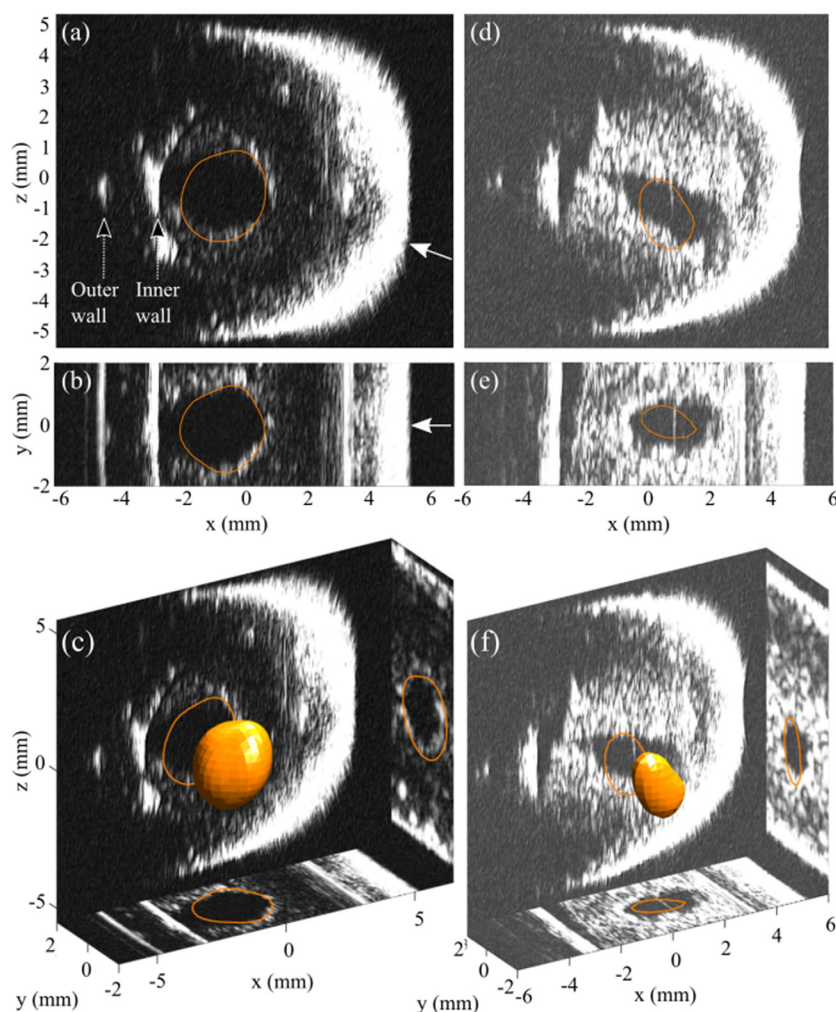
Time-averaged intensities at the -2 dB level overlaid on high frequency ultrasound images for long (a)–(c) and short (d)–(f) burst exposure sites. The contours in cross sectional views are shown as maximum intensity projections of the 3D surface of the -2 dB volume (c) and (f). Solid white arrows indicate the direction of acoustic propagation.
